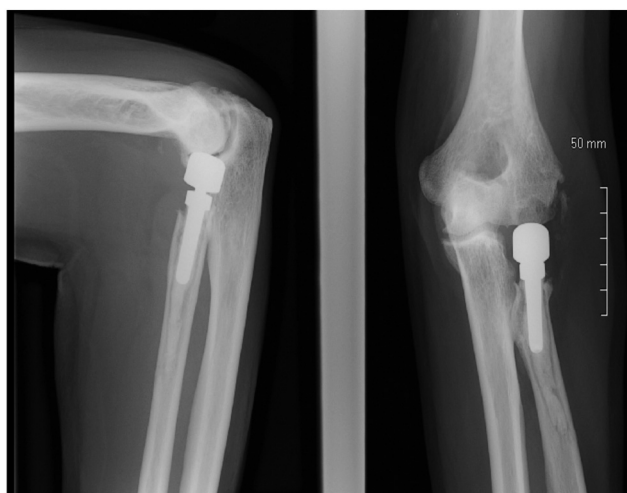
Radiograph showing a capitellar erosion opposite a radial head prosthesis implanted in an excessively high position.
